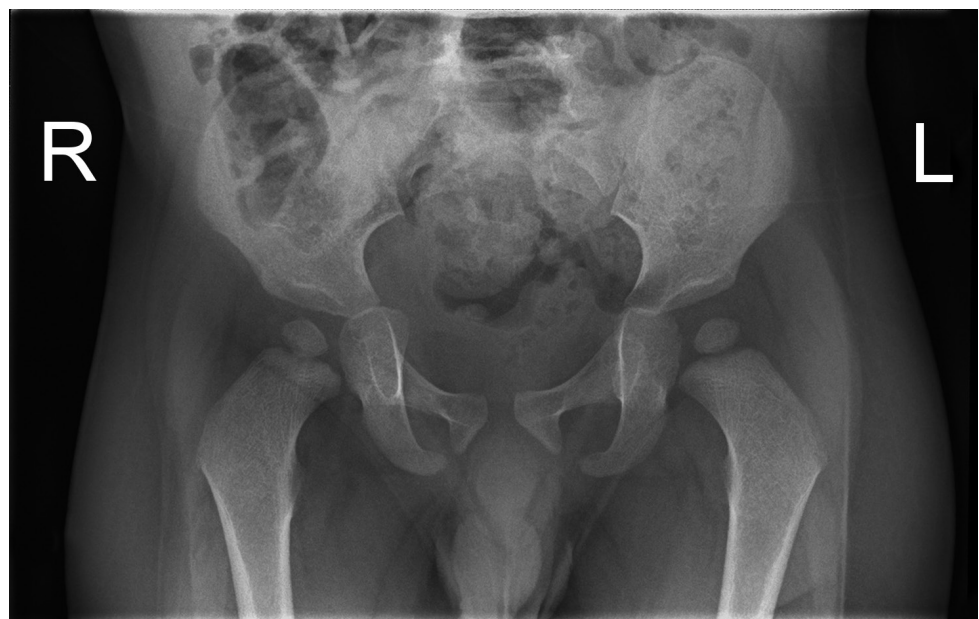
Radiograph showing left hip effusion.
